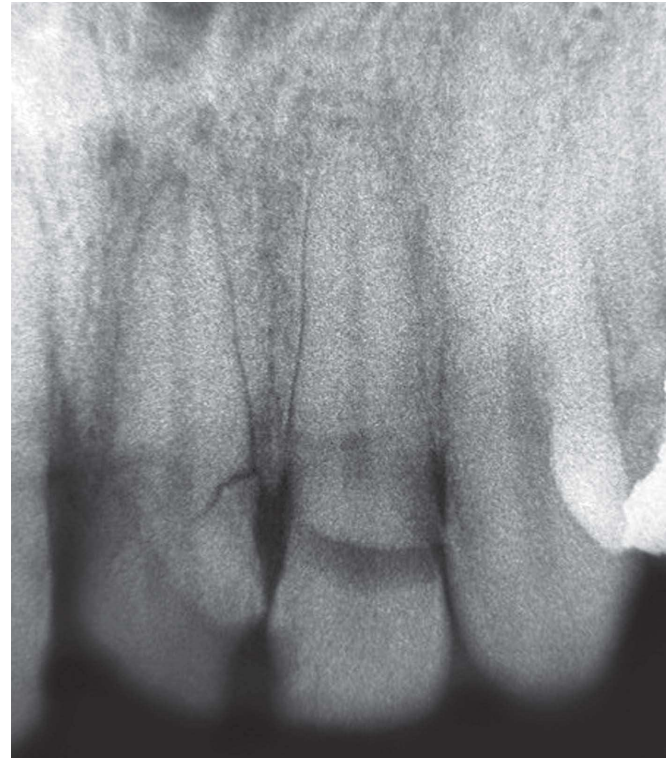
Periapical radiography of fractured unit 21. The level of fracture requires crown augmentation to the reestablishment of biological space, however the analysis of crown/root proportion contra-indicates the procedure.
